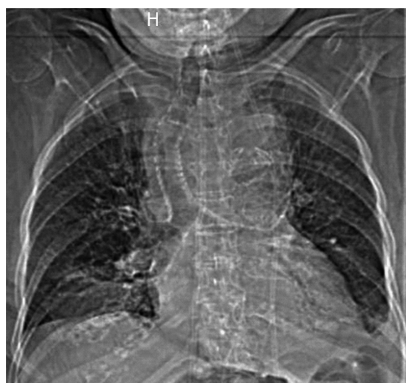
Chest radiography showed a widened mediastinum and tracheal deviation.
